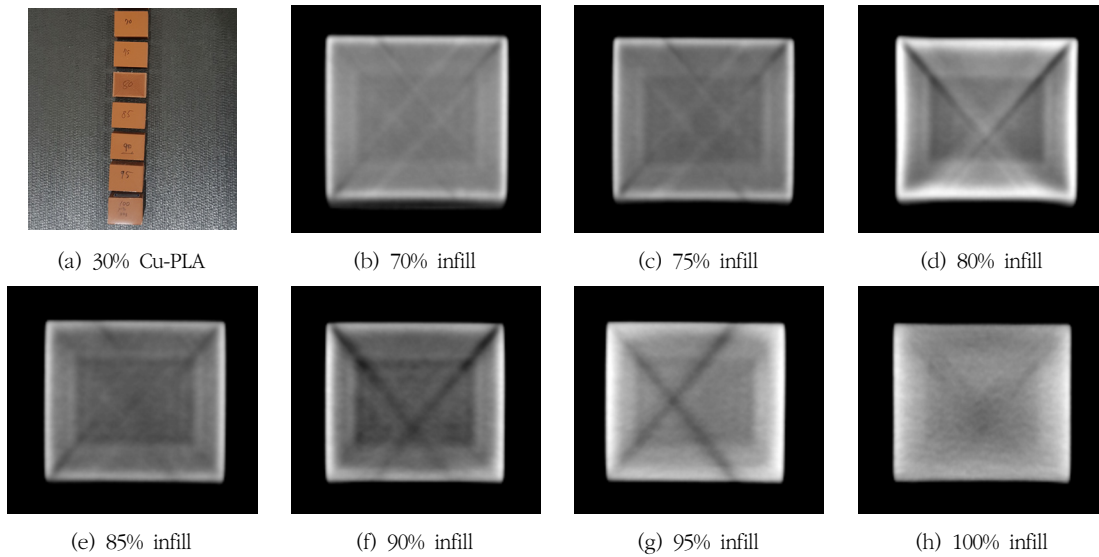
CT scan by infill of 30% Cu-PLA
